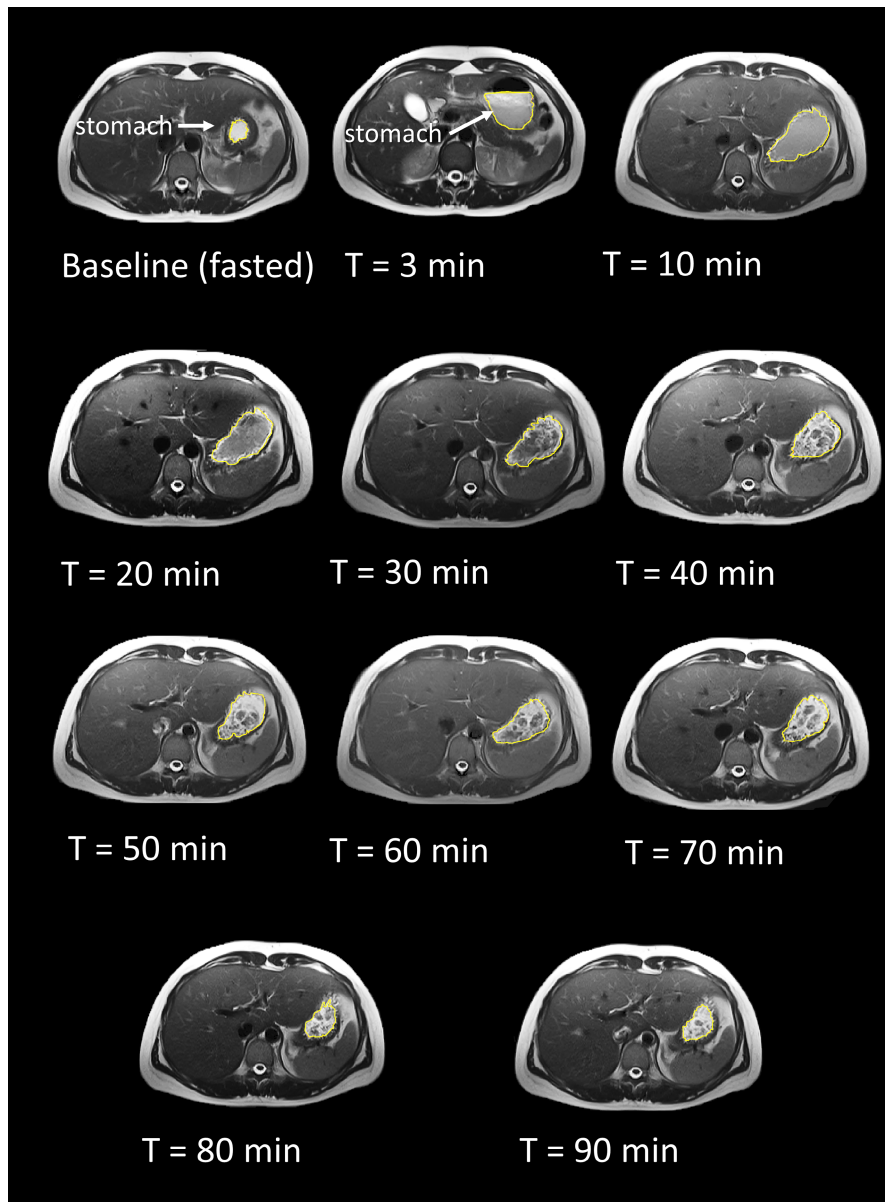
Examples of MR images of a subject with GI problems after drinking milk with panels showing the empty stomach (baseline), the stomach just after milk consumption ($T=3$ min), a homogenous filled stomach ($T=10$ min), the start of coagulation ($T=10-20$ min), and the formation of a strong coagulum ($T=30-90$ min).
